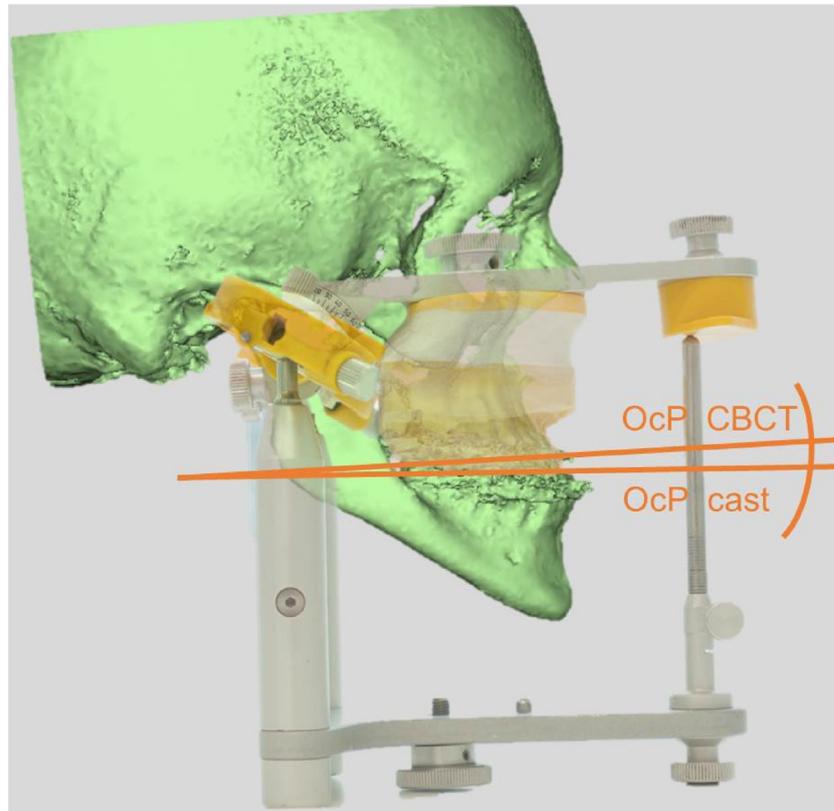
The difference between the patient's occlusal plane in the CBCT scan (OcP CBCT) and in the articulator (OcP cast). In most cases, the error of face-bow transfer resulted in articulated plaster casts with angles that were too steep.
